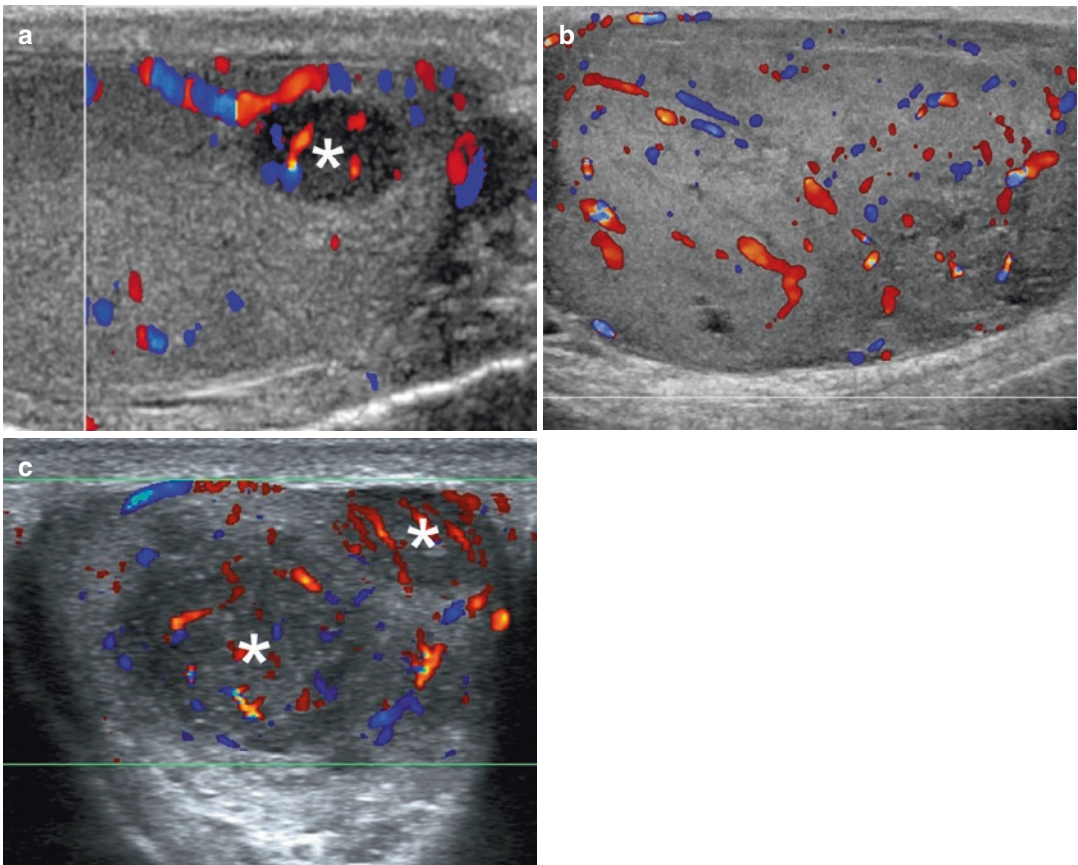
Seminomas with different ultrasonographic appearance. (a) Small hypervascular, hypoechoic lesion (asterisk). (b) Large tumor involving most of the testis. (c)
